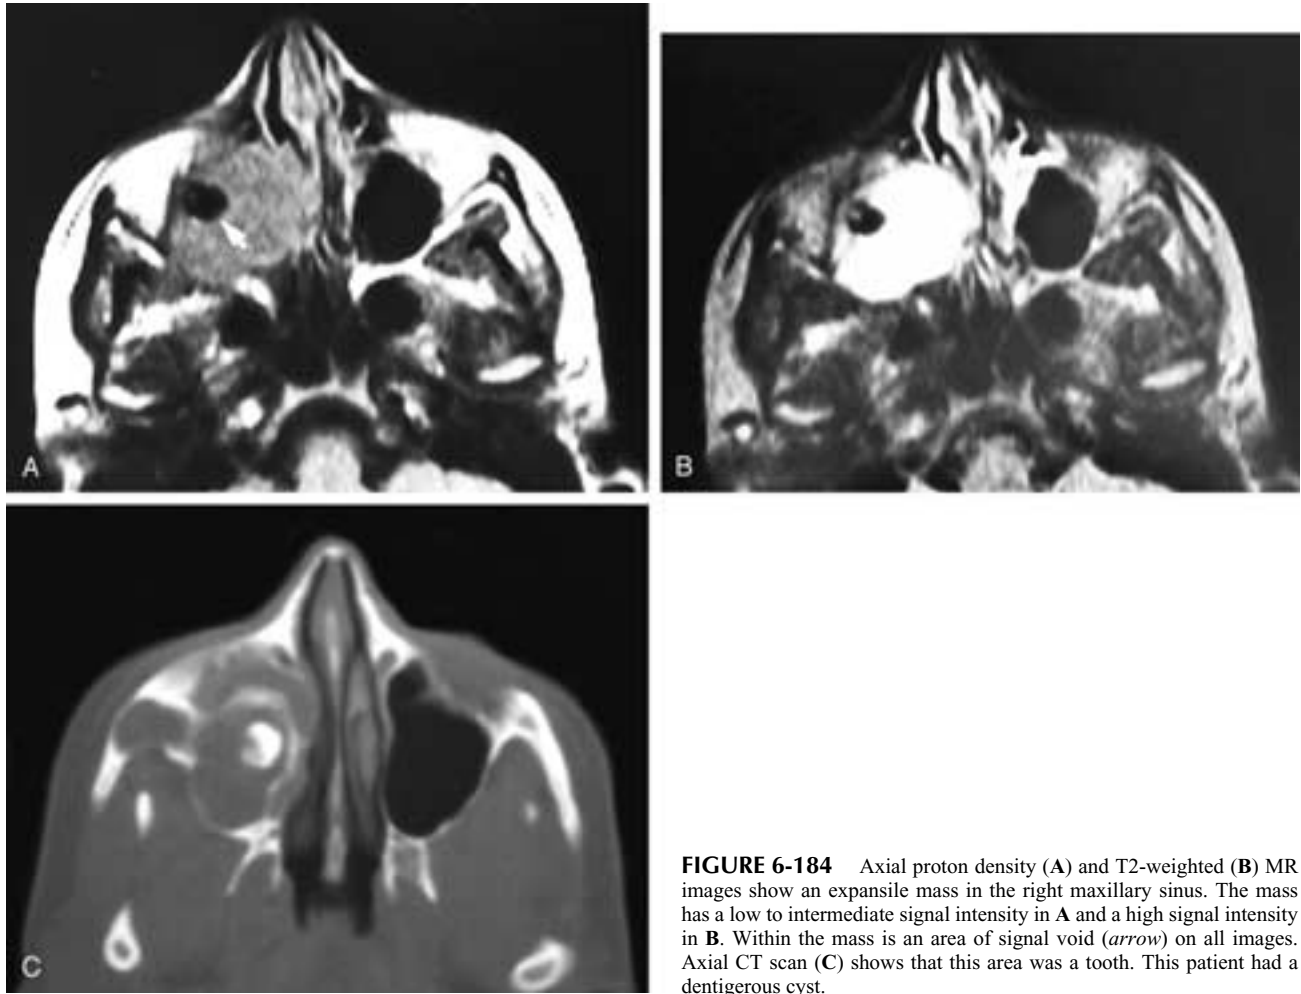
Axial proton density (A) and T2-weighted (B) MR images show an expansile mass in the right maxillary sinus. The mass has a low to intermediate signal intensity in A and a high signal intensity in B. Within the mass is an area of signal void (arrow) on all images. Axial CT scan (C) shows that this area was a tooth. This patient had a dentigerous cyst.
